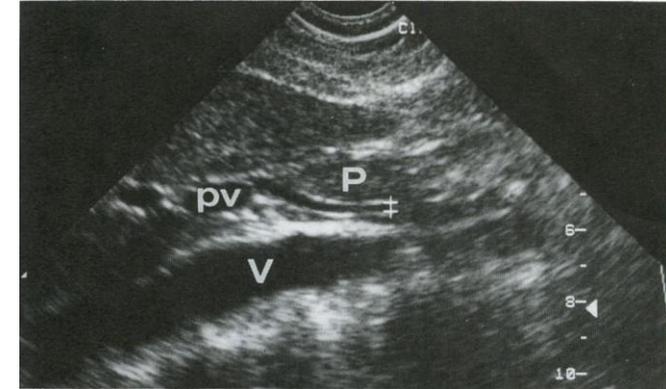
Longitudinal sonogram of normal pancreas. The pancreatic head (P) is seen just to the right of the midline. The common bile duct (‡) arches over the portal vein (pv) and descends to the posterior pancreatic head just anterior to the inferior vena cava (V).
